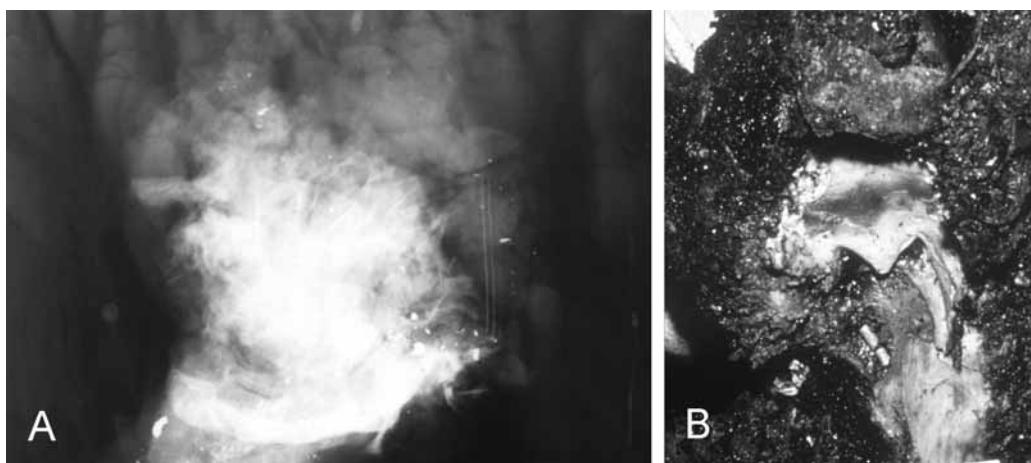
Dead prior to fire. Apparent accidental car fire concealing a homicide. No evidence of smoke and carbon monoxide inhalation. (A) Radiograph of skull. Multiple bullet fragments. (B) Top of skull burnt and missing. Probe inserted through gunshot hole in base of skull showing track to recovery site of largest bullet fragment (courtesy of the Office of Chief Medical Examiner, Chapel Hill, NC).
